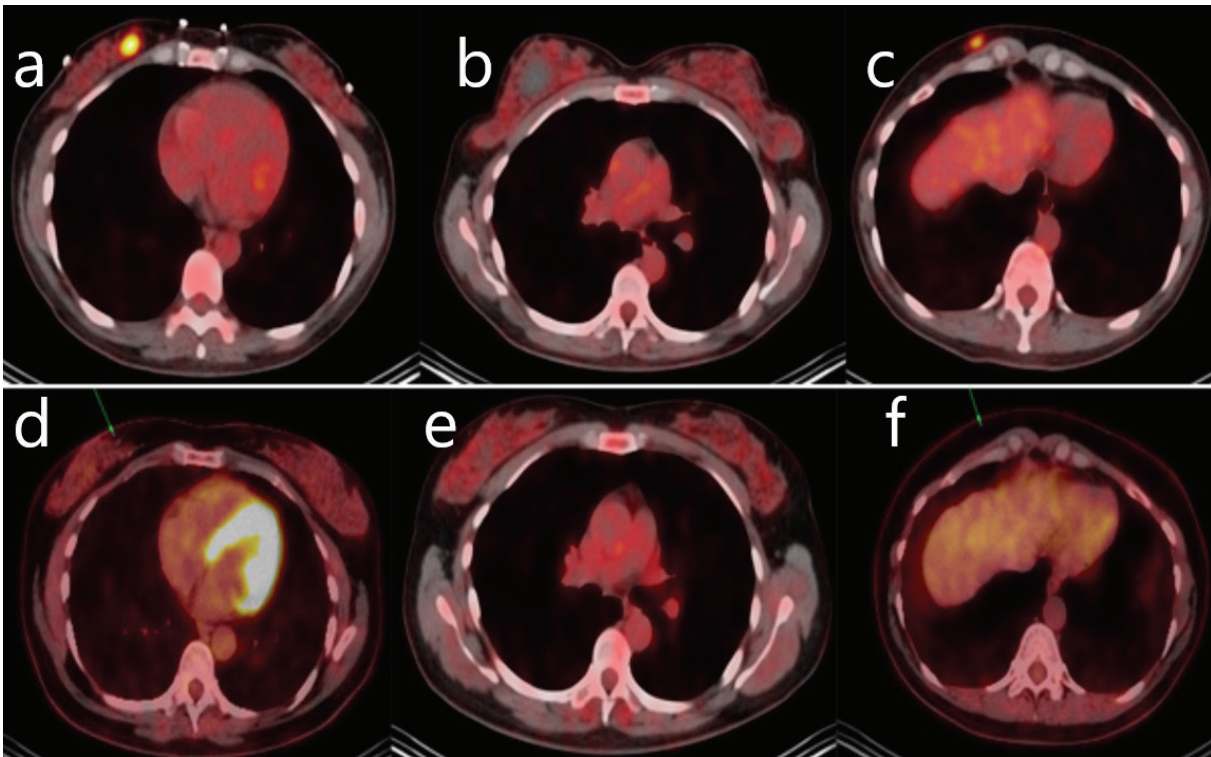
^{18}F -FDG PET/CT scanning performed for staging at the beginning (a, b, c) and 4.5 months after the first one performed for neoadjuvant treatment response evaluation (d, e, f). A hypermetabolic lesion was observed in the lower inner quadrant of the right breast that was compatible with primary tumor (SUV_{max} : 10.5) (a). The primary tumor was reduced in size and its ^{18}F -FDG uptake was markedly decreased after neoadjuvant chemotherapy (d). Several hypometabolic cystic lesions were also observed in both breasts at the beginning. These lesions were interpreted as benign cystic lesions (fibrocystic changes?) (b). The hypometabolic cystic lesions were reduced in size at the second imaging (e) and confirmed by the postoperative pathology report. A 12 mm diameter hypermetabolic nodular lesion was observed in subcutaneous fatty tissue under the skin at the level of the 6th rib on the right anterior wall of the thorax at the initial imaging (SUV_{max} : 4.7) (c). This lesion was interpreted as an intramammary lymph node metastasis (c). This nodular lesion disappeared on second imaging (f).
